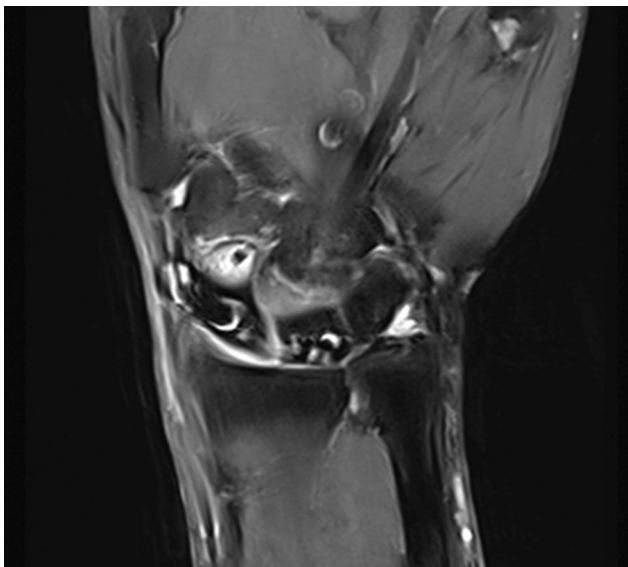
Control MRI scan at 3 months.
